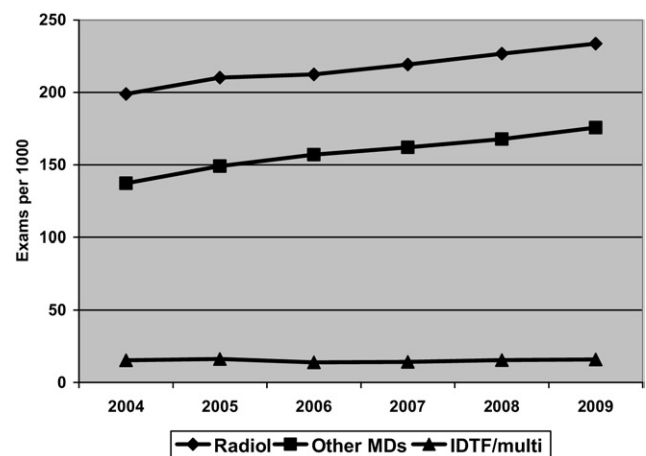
Medicare utilization rates of noncardiac ultrasound, 2004 to 2009. All places of service are included. Trend lines compare use by radiologists, all nonradiologist physicians, and IDTF/multi facilities. IDTF/multi = independent diagnostic testing facilities and multispecialty groups; other MDs = all other physicians; Radiol = radiologists.
